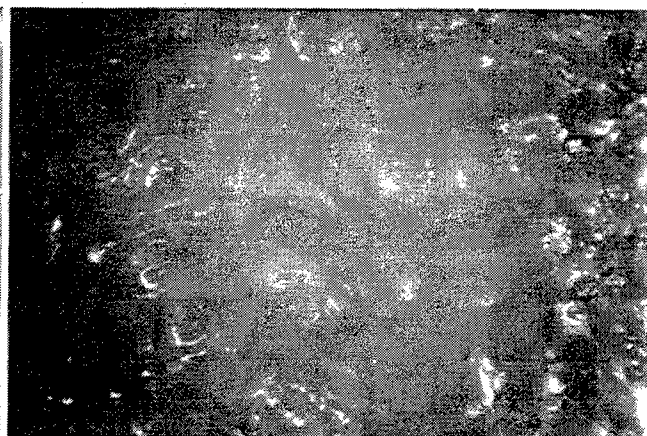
Coagulation of ultrasound fragmented liver tissue by Nd:YAG-laser radiation
